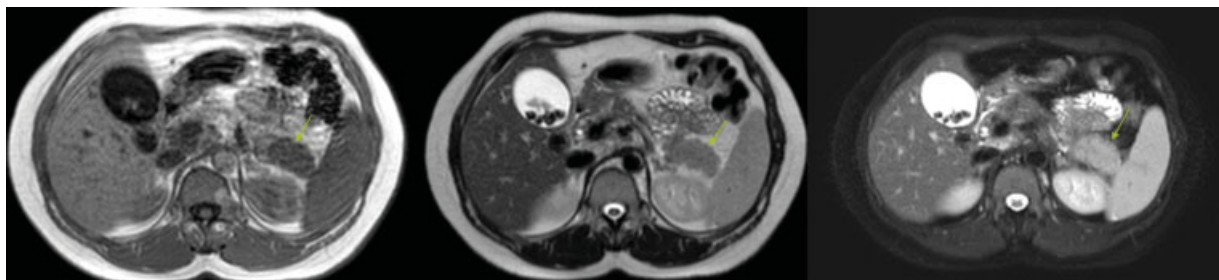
The intensity of lesion was similar to spleen on the T1-weighted gradient-echo (GRE) in-phase, T2-weighted image, and T2 fat-saturated sequence.
